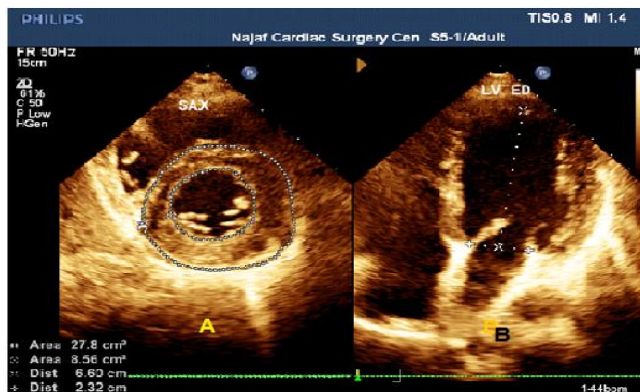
(A) Short-axis view of the left ventricle, at end-systole. (B) Apical four chamber view to assess LV diastolic length.
